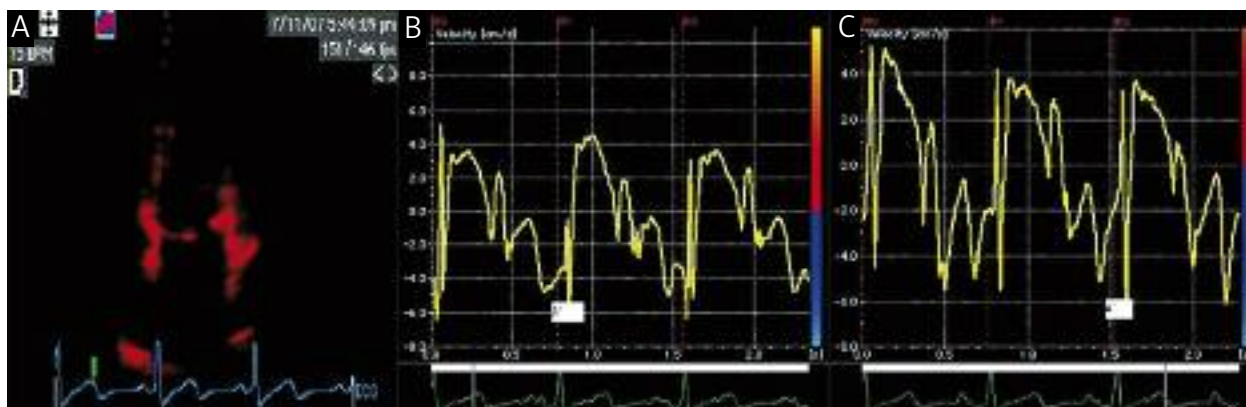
Colour tissue Doppler image of left atrium in the apical 4-chamber view (A), TDI velocity of septal wall before (B) and after the procedure (C)
